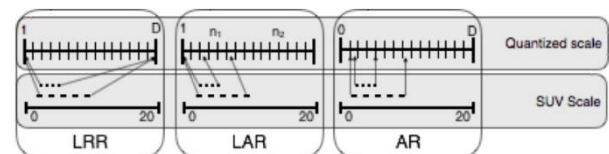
Comparison of quantisation algorithms: The lesion relative resampling method (LRR) normalises the range of SUV values for each VOI to a fixed number of bins, resulting in variable bin sizes across VOIs as well as a loss of consistent SUV scaling. Lesion absolute resampling (LAR) uses a fixed bin size for all VOIs, but assigns the first bin to the SUVmin of the lesion, leading to a variable number of bins as well as the loss of relative SUV values between lesions. Absolute resampling (AR) uses a fixed SUV scale, bin size and number of bins, meaning relative SUV values are preserved across VOIs after quantisation.
